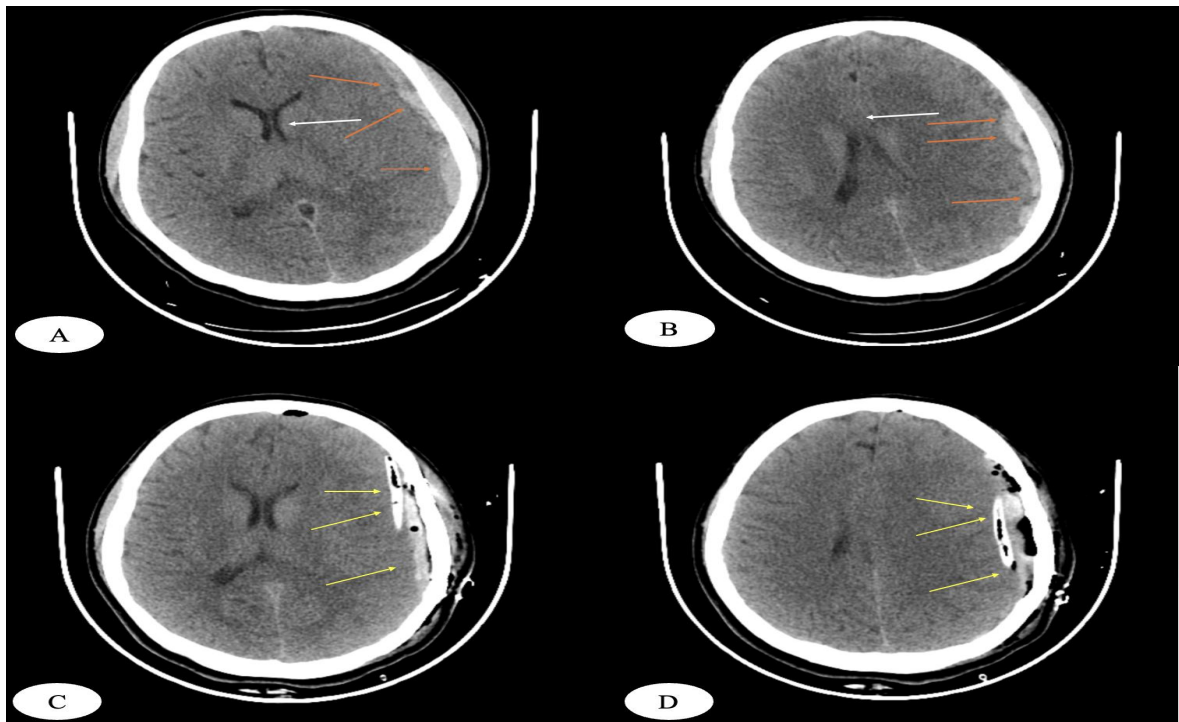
Preoperative cranial CT images
